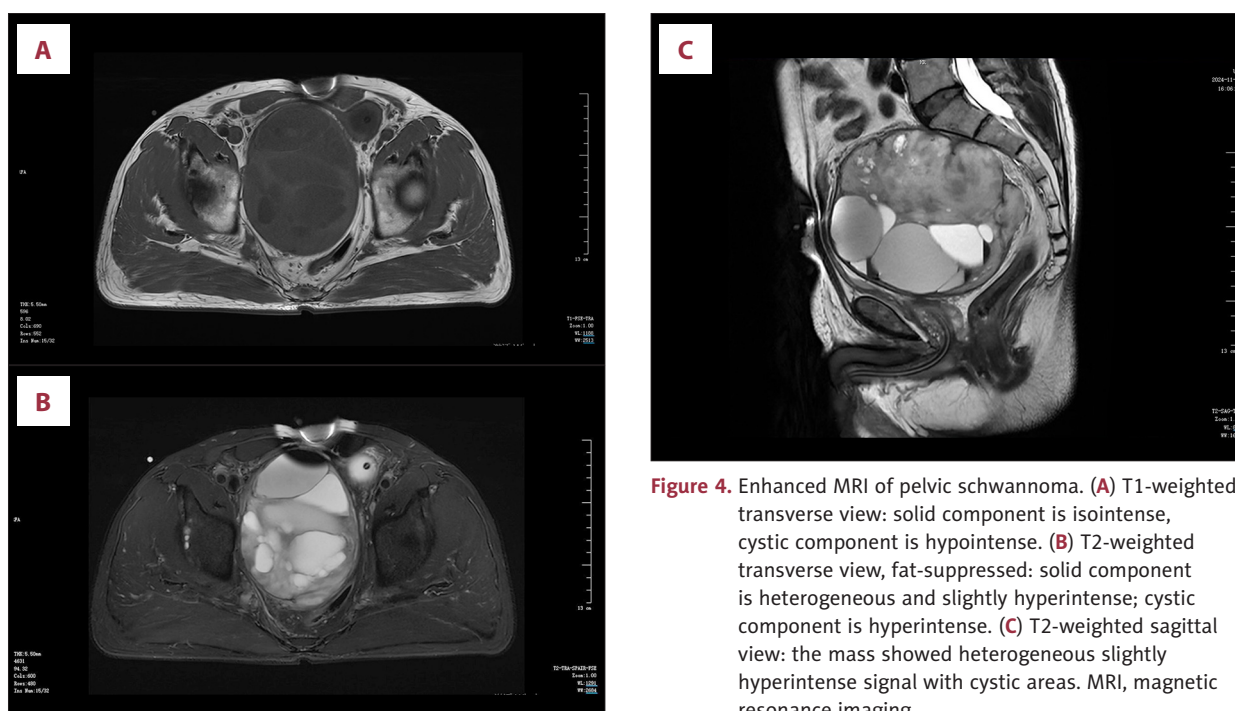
Enhanced MRI of pelvic schwannoma. (A) T1-weighted transverse view: solid component is isointense, cystic component is hypointense. (B) T2-weighted transverse view, fat-suppressed: solid component is heterogeneous and slightly hyperintense; cystic component is hyperintense. (C) T2-weighted sagittal view: the mass showed heterogeneous slightly hyperintense signal with cystic areas. MRI, magnetic resonance imaging.
